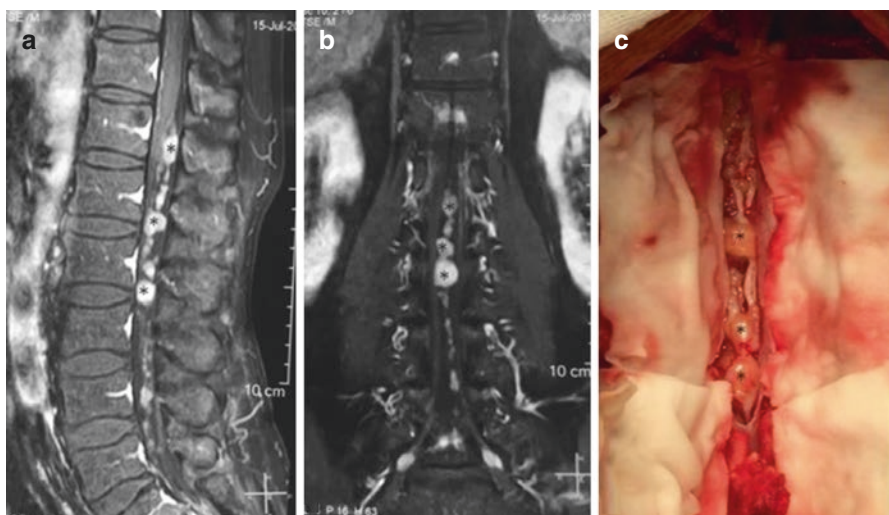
Sagittal (a) and coronal (b) MRI with gadolinium identifies multiple lesions in the lumbar spinal canal. Intraoperative view of the neurofibromas (c)
